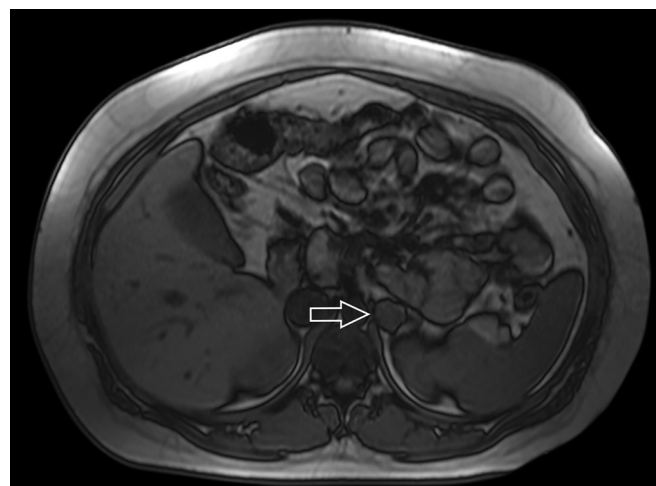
MRI T1 out of phase image w/o contrast obtained while patient was 33 weeks pregnant. A 1.9 x 1.9 cm lesion within the left adrenal gland that does not demonstrate significant signal loss on out of phase imaging
